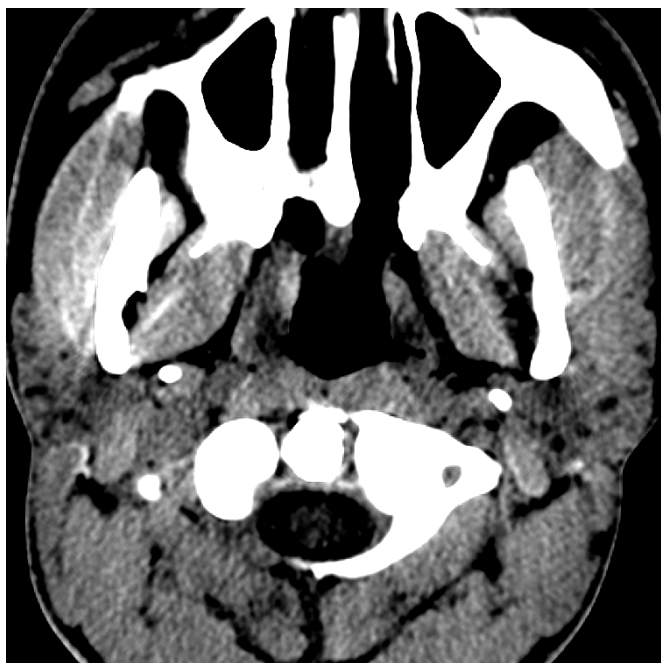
Axial postcontrast CT in a child with HIV infection secondary to blood transfusions demonstrates multiple, bilateral low attenuation cysts throughout both parotid glands, typical of lymphoepithelial lesions in HIV-positive patients.
